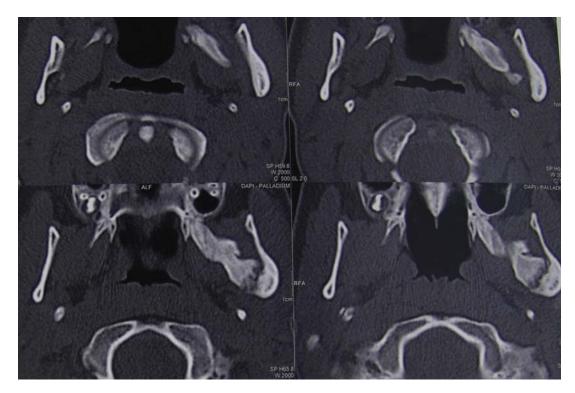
Axial CT scan showing the myosistis on the left side.
